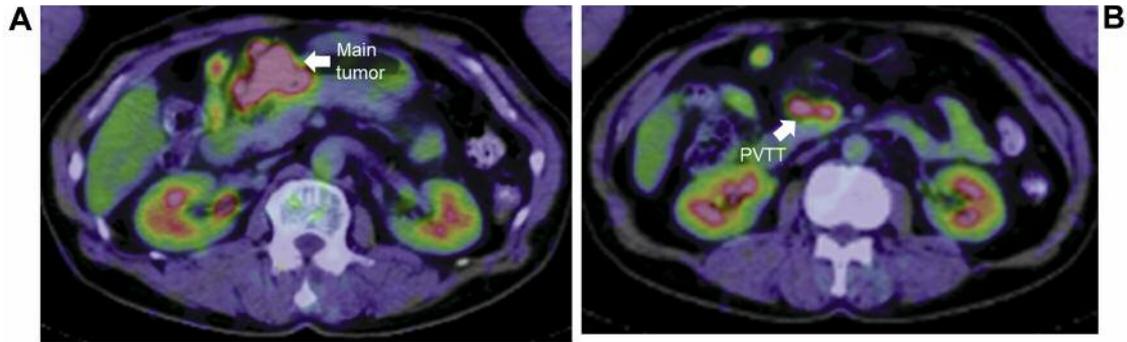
Fluorodeoxyglucose-positron (FDG) emission tomography. A. Main tumor. B. Portal vein tumor thrombosis (PVTT). The main tumor and PVTT showing abnormal uptake of FDG. The maximum standardized uptake values of the main tumor (arrow) and PVTT (arrow head) are 9.9 and 6.9, respectively.
